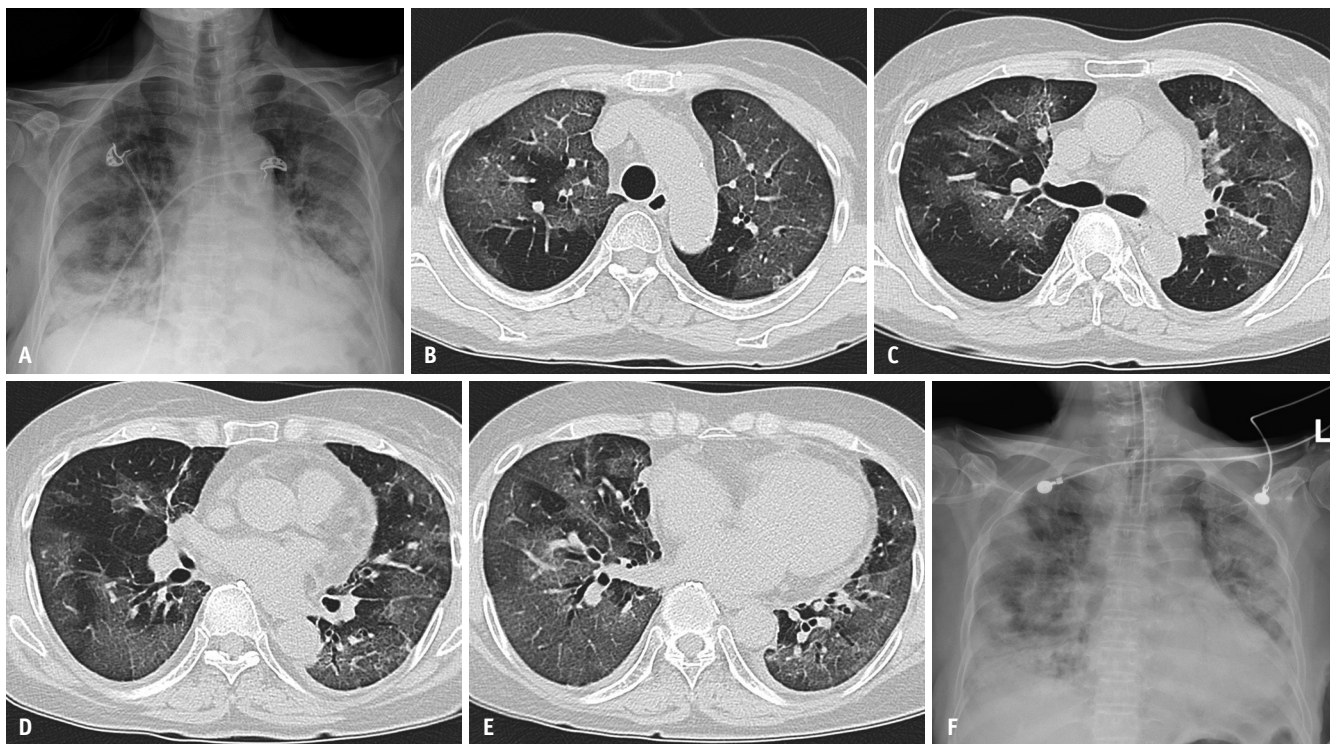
COVID-19 pneumonia during the Omicron variant-dominant period in a 69-year-old female patient with a history of kidney transplantation. A: Initial chest radiograph showing a multifocal area of GGO in the bilateral lungs. The case was classified as ‘severe pneumonia’ ($\geq 25\%$ lung involvement) based on the modified 3-point visual scoring system. B-E: Lung window images of a transverse non-enhanced chest CT scan obtained at admission showing diffuse and extensive areas of GGO with intralobular interstitial thickening (crazy-paving pattern) involving bilateral lungs. CT findings were classified as “typical” according to the Radiological Society of North America chest CT classification system. F: Follow-up chest radiograph taken 1 day later demonstrating extensive GGO and consolidation in bilateral lungs. The patient was placed on mechanical ventilation the same day due to worsening of dyspnea, but progressed to acute respiratory distress syndrome, and finally succumbed to the disease. GGO = ground-glass opacity
